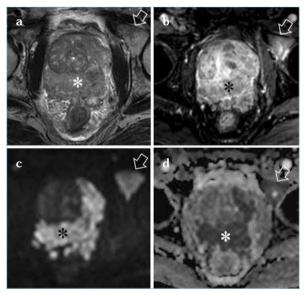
a-d. Multiparametric MRI showed an extensive lesion (*) affecting the peripheral zone of the prostate from the base to the apex, and infiltrating the adjacent anatomic structures. Three cores of the right lobe and five cores of light lobe of the prostate gland showed usual prostatic adenocarcinoma with neuroendocrine differentiation. The lesion appears hypointense on T2weighted imaging (a), has inhomogeneous enhancement on DCE sequences (b), appears hyperintense on DW MRI (b value=2000 s/mm²) (b) and hypointense on the ADC map (c), indicating restricted diffusion. DW MRI (c, d) and T2-weighted MRI (a) were sufficient to indicate biopsy and further work-up. Note the metastasis in the left ischiatic branch (arrow)
